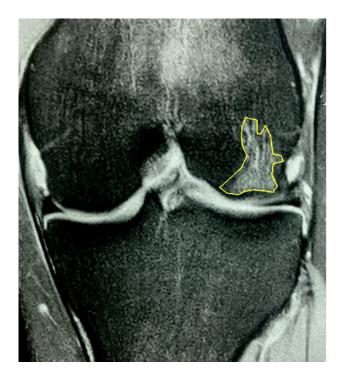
Proton-density coronal magnetic resonance imaging scan showing hyperintense region of interest (outlined in yellow) for the lateral femoral condyle.
